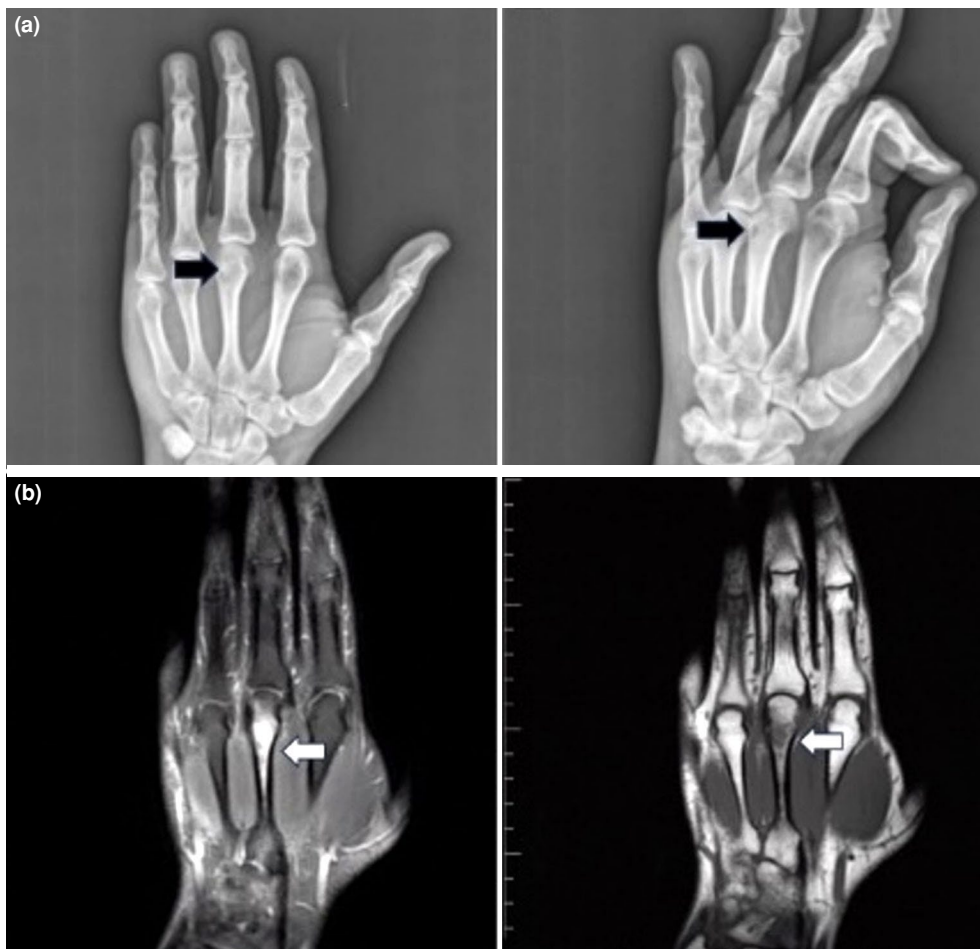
Radiological images of the hand before surgical intervention. (a) Anteroposterior and oblique radiographs of the hand taken during the preoperative diagnosis phase of the case; two black arrows show the sequestered bone tissue on the dorsal side of the third metacarpal of the hand with a preliminary diagnosis of osteomyelitis. (b) Magnetic resonance imaging T1 and T2 images taken during the perioperative diagnosis phase, from left to right, respectively; two white arrows, destruction caused by osteomyelitis in the bone, cortical irregularity, and metacarpal distal ulnar cortex lysis.
